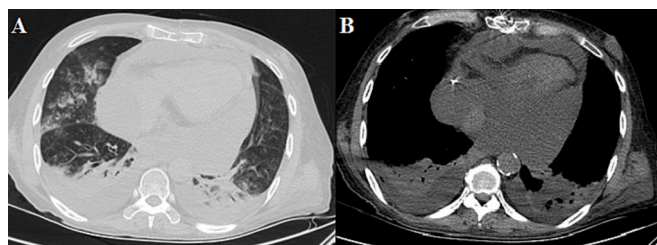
Chest computed tomography (CT) shows evidence of pericardial effusion and bilateral pleural effusion. Evidence of sternal defect due to coronary artery bypass graft (CABG) surgery is obvious. A) lung window, B) mediastinal window.
